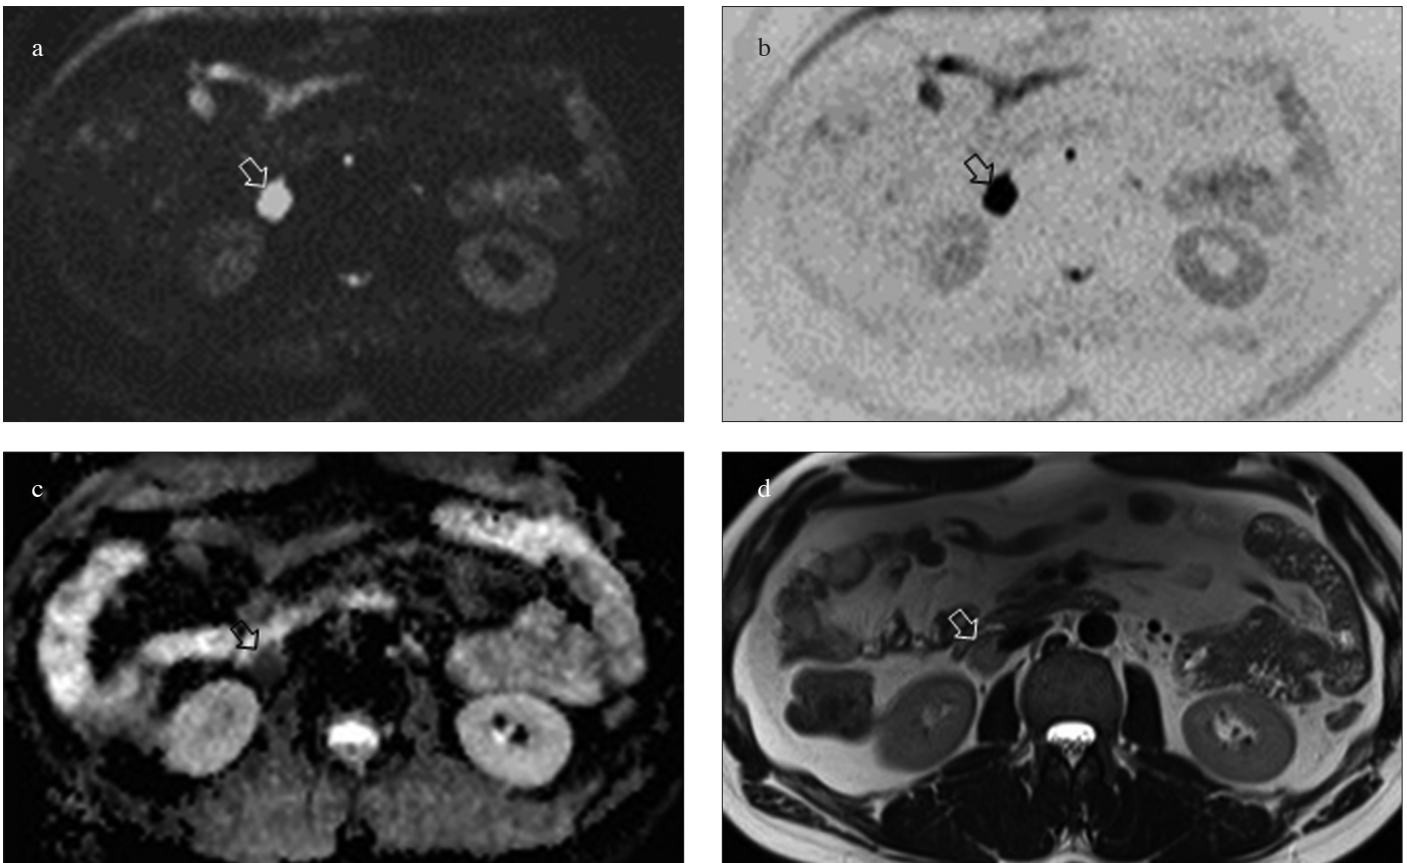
a-d. Abdominal biparametric 3T magnetic resonance imaging in a 26-year-old man with seminoma after radical orchiectomy. Enlarged right retroperitoneal lymph node is detected on diffusion-weighted imaging (DWI) with high b-values (arrow in a), DWI with high b-values inverted (arrow in b), diffusion apparent coefficient map (arrow in c) and localized on T2-weighted imaging (arrow and head arrow in d)
